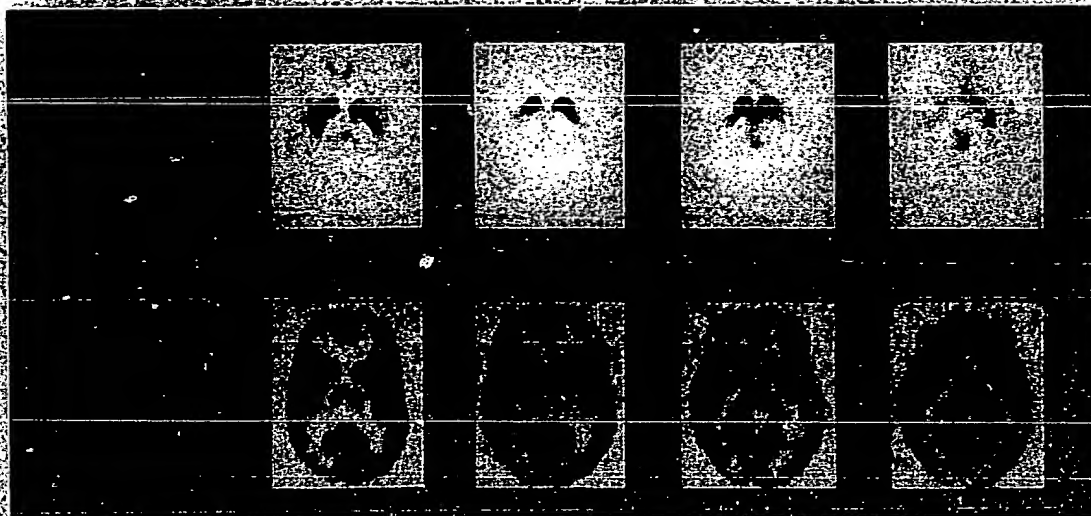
6-L-[¹⁸F] Fluorodopa (F-dopa) and fludeoxyglucose F-18 (FDG) positron emission tomographic scans performed 9 months after surgery. The upper series of slices are integrated uptake of fluorodopa, 60 to 120 minutes after drug injection, while the lower show FDG uptake integrated over 30 to 60 minutes. Each slice is 6.7 mm thick with the section on the left most dorsal and the right most ventral. The left side of each image is the right side of the patient's brain. Fetal implant was in the right caudate and putamen. In-plane image resolution is 8.54 mm. The FDG images provide anatomic detail against which the fluorodopa images can be assessed. In all planes, fluorodopa uptake in the caudate nucleus is substantial bilaterally. In the putamen, uptake is less and appears asymmetric, with greater uptake on the patient's right side in two of the three sections showing the putamen. Detailed calculations are presented in the "Results" section.
